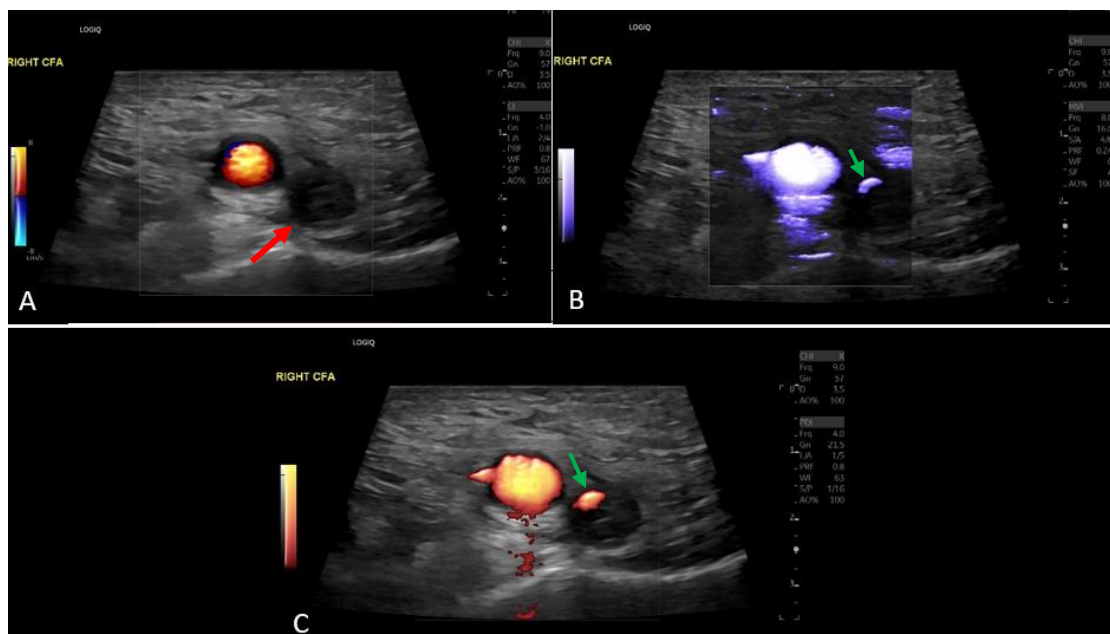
CFV DVT in axial plane. Color doppler in A displaying no visible flow inside the lumen of the CFV (red arrow). SMI in B and Power doppler in C techniques at the same level with A, showing a small pocket of low-velocity blood flow in the periphery of the partially thrombosed lumen not visible in color doppler technique (green arrows). SMI and Power doppler techniques can detect flow of lower velocity compared to color doppler, an asset to differentiate between complete and partial venous thrombosis.
